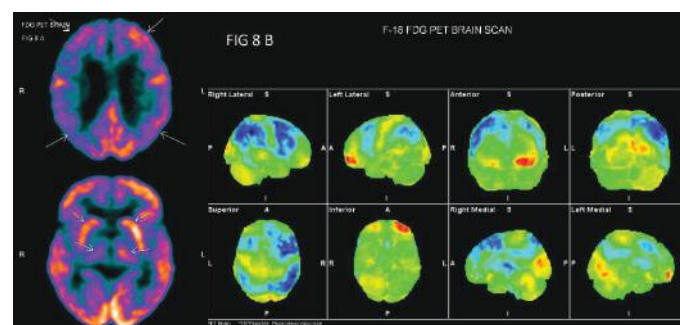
FDG PET brain scan (figure 8a and 8b) demonstrate asymmetric hypo metabolism in bilateral cortical and subcortical structures
